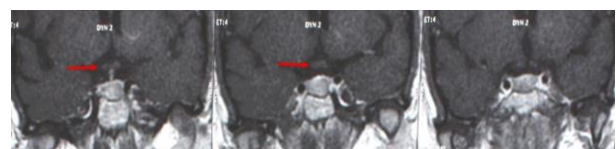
Case 2, Coronal MRI with contrast showing lesion 1.1 X 0.5 X 0.3 cm with no chiasm compression (Red arrow).
